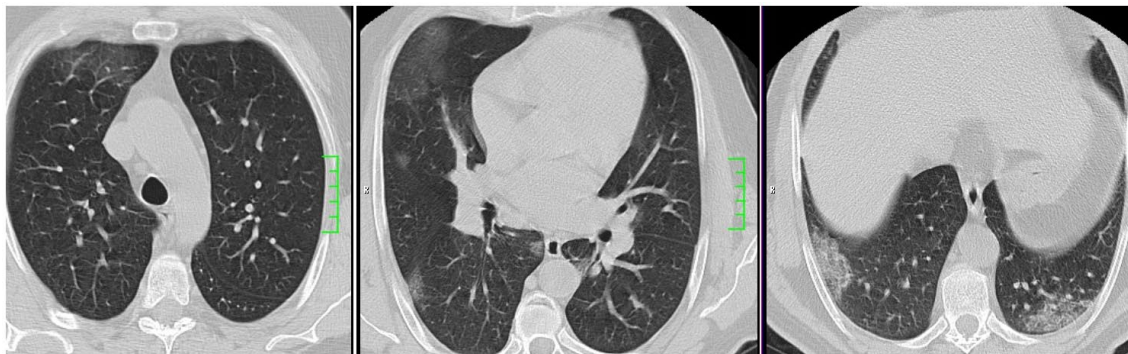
52-year-old man with COVID-19 pneumonia. Axial CT images shows bilateral, multilobar, peripheral and central, patchy ground-glass opacities. COVID-19 chest CT severity score is "7"
